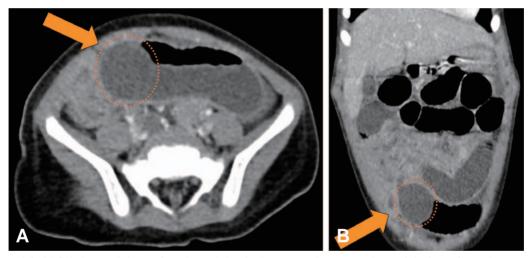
A round fluid-filled material was found on abdominal computed tomography: axial view (A) and coronal view (B). Arrows indicate: suspected jelly water bead
